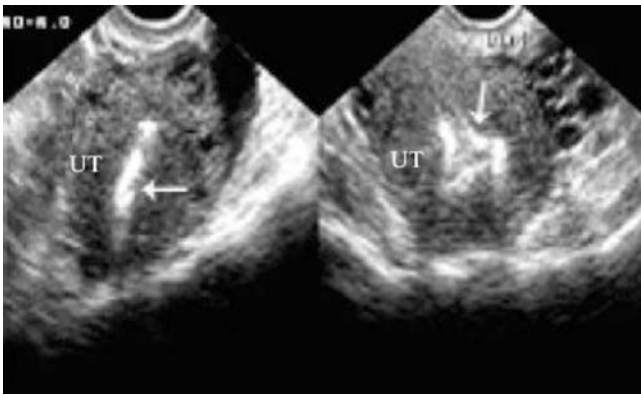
Intrauterine device. Sonogram shows an “T”-shaped hyper-echoic IUD in the uterine cavity on the longitudinal view, which shows a hyper-echoic triangle on the transverse view
